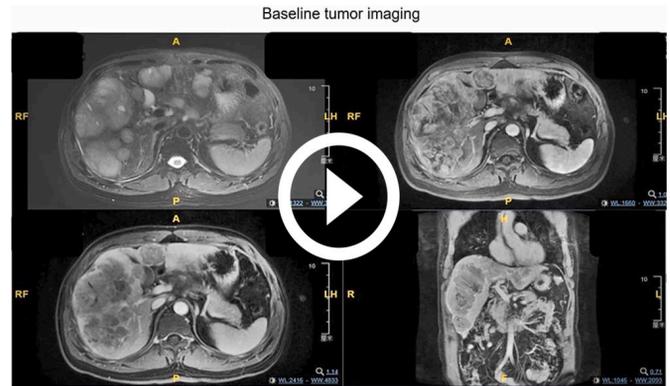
A 47-year-old man (tumor size on MRI scan, 22.8 cm × 10.6 cm; ECOG-PS, 2; Child-Pugh A stage) with large intrahepatic tumor diagnosed with pathologic hepatocellular carcinoma by a core need biopsy (A) and treated with first-line HAIC-FO therapy (B). HAIC-FO, interventional hepatic arterial infusion chemotherapy of FOLFOX regimens; HCC, hepatocellular carcinoma.
